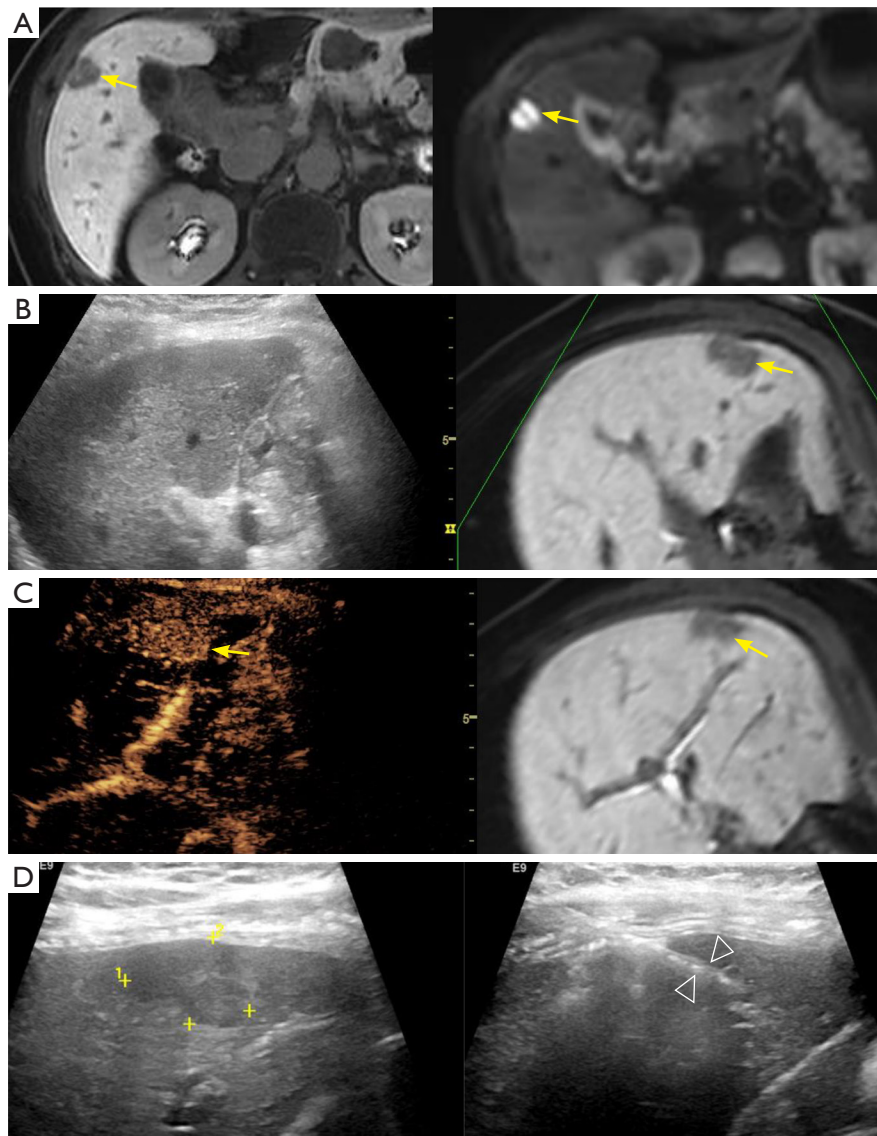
A-69-year-old female with a 12-year history of postoperative duodenal carcinoma. (A) A focal liver lesion (0.9 cm) detected by magnetic resonance imaging (yellow arrows: the target lesion). (B) The target lesion appeared inconspicuous on B-mode ultrasound fusion (yellow arrow: the target lesion). (C) A nodule with hyperenhancement was identified on contrast-enhanced ultrasound fusion (yellow arrows: the target lesion). (D) Biopsy was performed under the guidance of high-frequency ultrasound (white arrowheads: biopsy needle).
